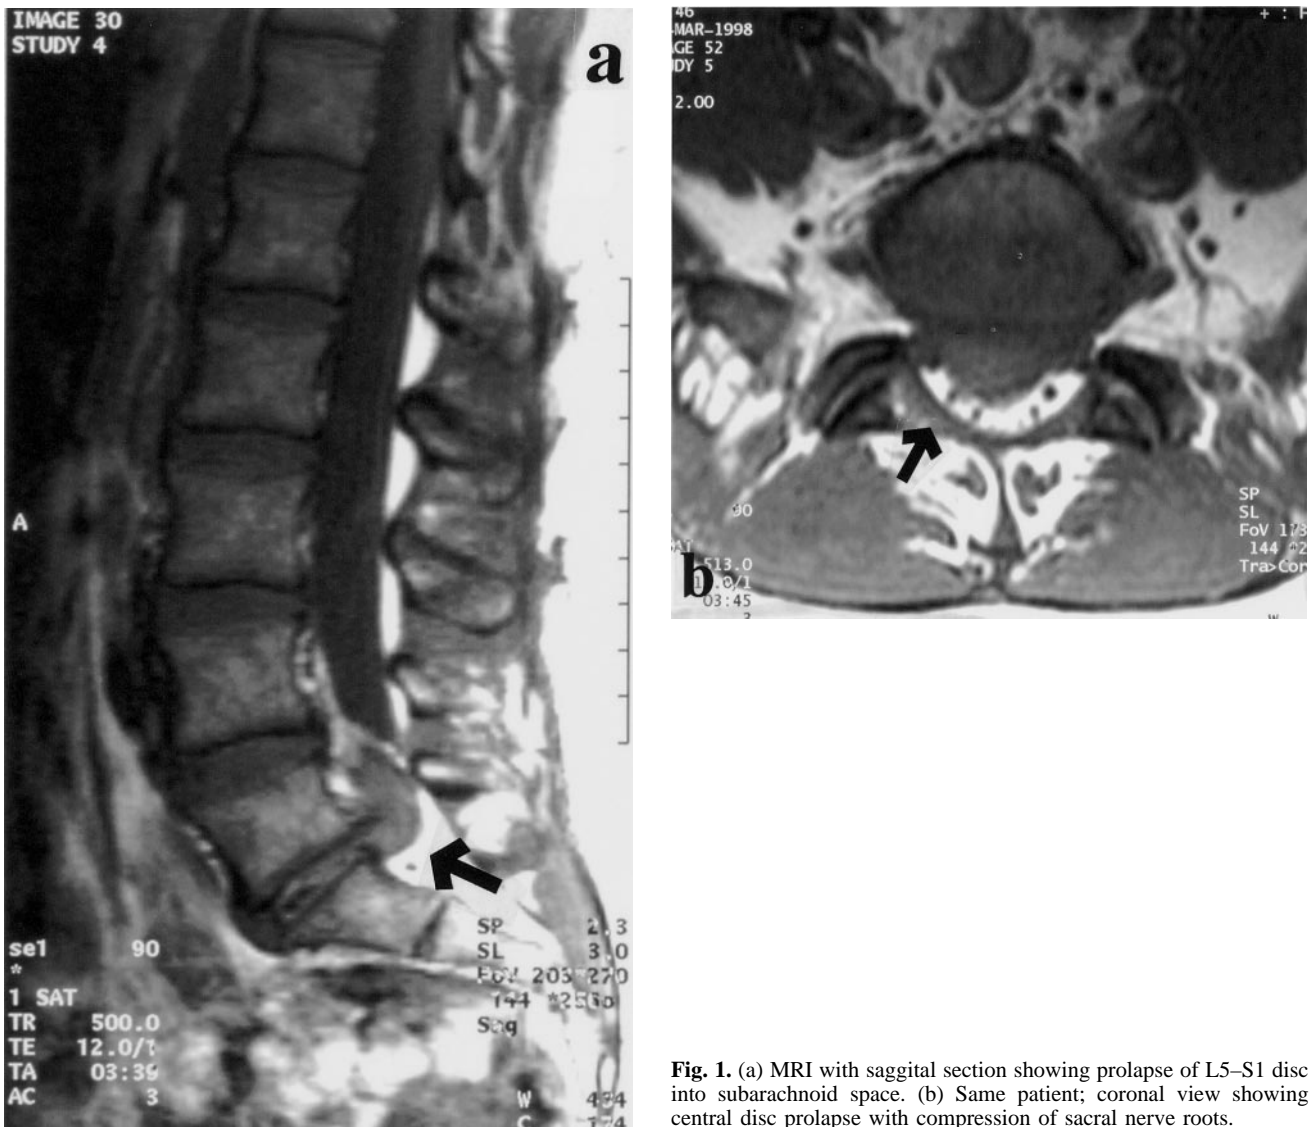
(a) MRI with sagittal section showing prolapse of L5–S1 disc into subarachnoid space. (b) Same patient; coronal view showing central disc prolapse with compression of sacral nerve roots.
